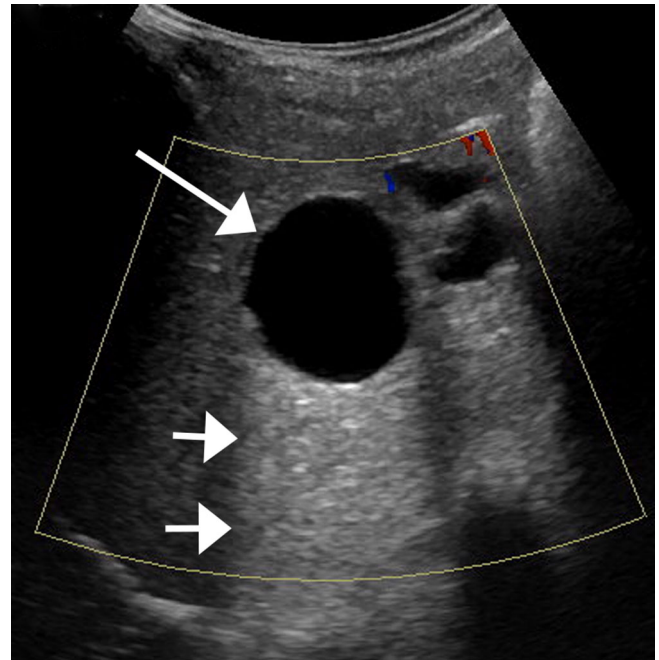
LI-RADS US-1: Negative. A 79-year-old female with chronic hepatitis B. Ultrasound image with *color Doppler* shows focal observation larger than 1 cm (*long arrow*). Ultrasound features are classic for benign hepatic cyst, including anechoic appearance; posterior acoustic enhancement (*short arrows*); imperceptible wall; and lack of color flow (image reproduced with permission by the ACR).
